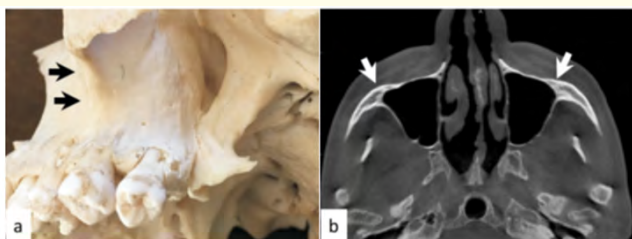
Maxillary sinus and zygomatic process- dry skull and CT images.
